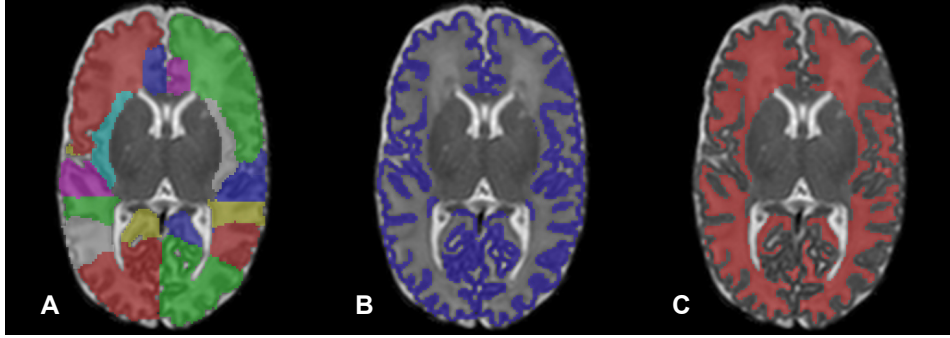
Example of segmented WM/CGM structures (A) and the corresponding superlabels for CGM (B) and WM (C) in the axial plane of a T2-weighted MRI.
